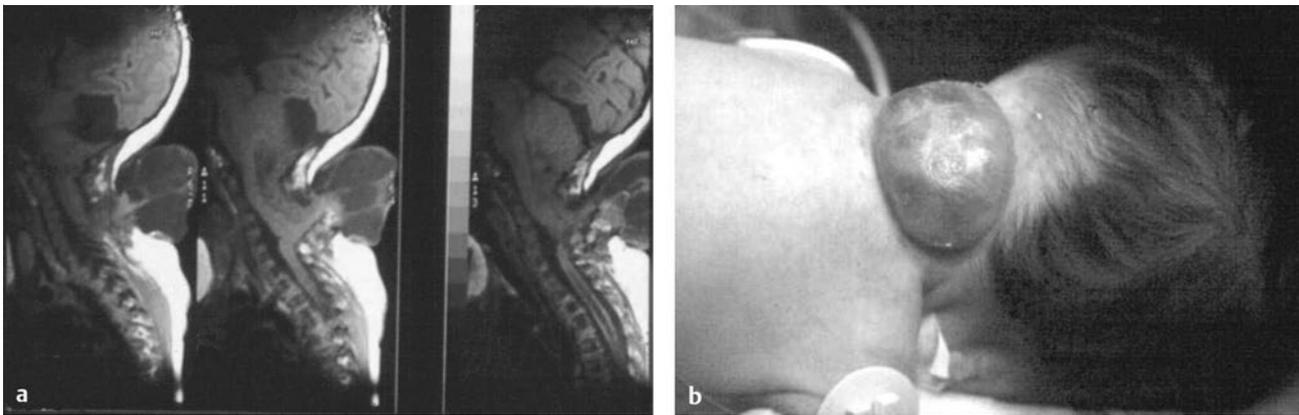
(a) Sagittal magnetic resonance images and clinical image of a type 3 Chiari malformation, (b) with hindbrain herniation through an upper cervical spina bifida.
